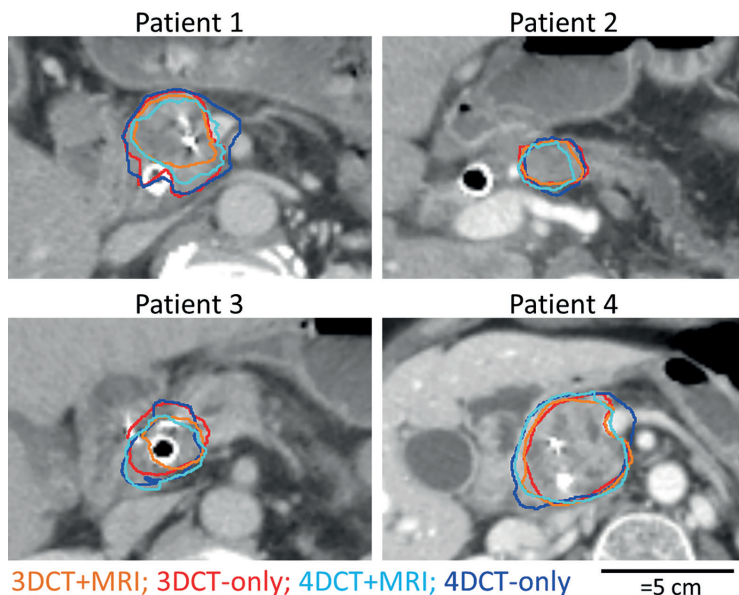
For each patient, median surfaces for CT+MRI study (orange and light blue) and the CT-only study (red and dark blue) are shown.
